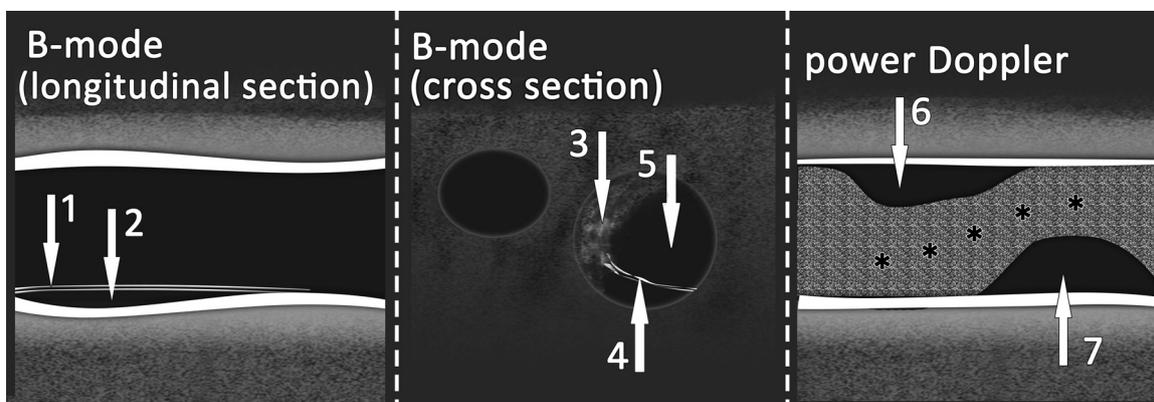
Gray-scale US graphical representation of CAD. B-mode ultrasound longitudinal section shows intima-media complex (1) and intramural hematoma (IH) (2). Cross section image reveals echogenic intraluminal thrombus formation (3), intimal flap (4), and residual arterial lumen (5). Black asterisks in the power Doppler image indicate impaired blood flow due to IH (6,7).
